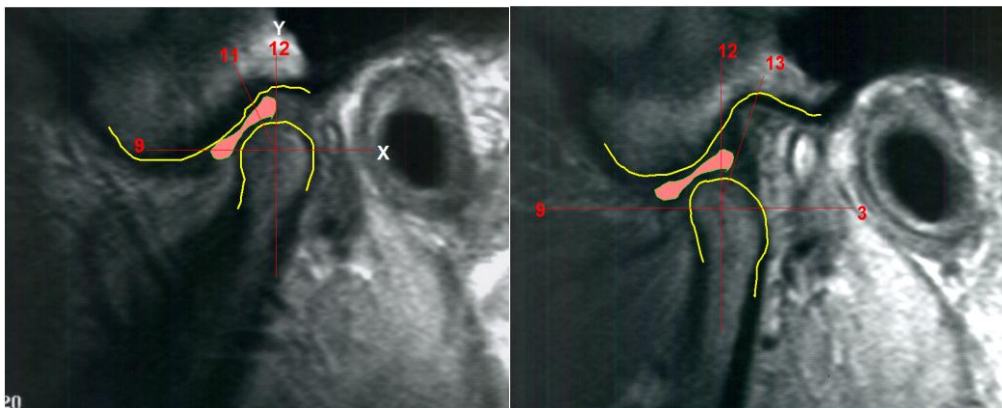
MR image of a sound temporomandibular joint in the centric relation, physiologic position of the condyles and disco–condylar relation with closed mouth (a) and open mouth (b).
